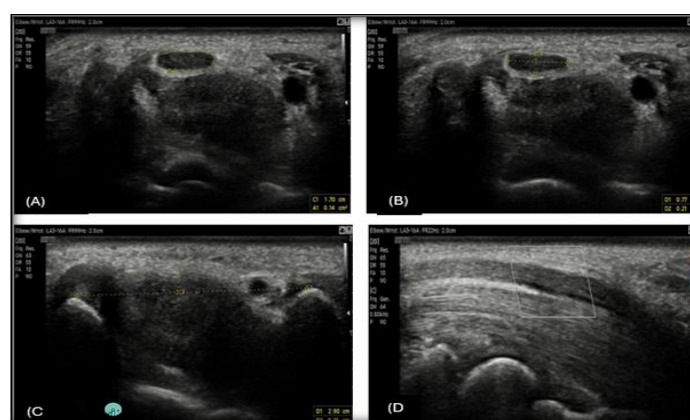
Ultrasound and Doppler findings in Grade III CTS patient
